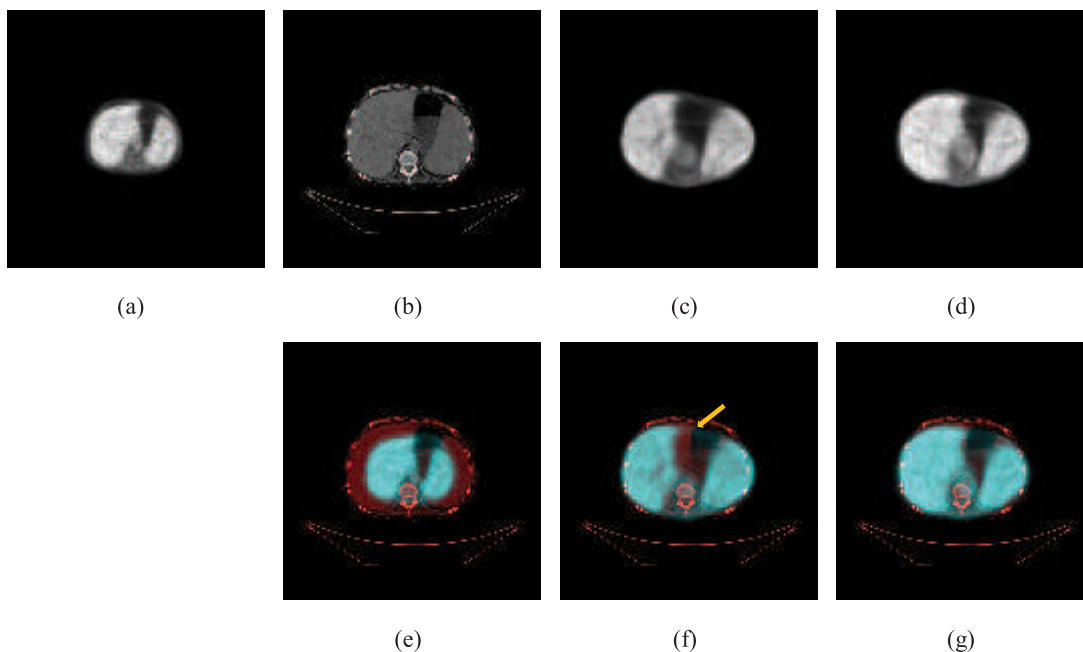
An example of PET/CT registration results with and without distribution similarity (DS) term. (a) The source PET image. (b) The source CT image. (c) The registration result without DS. (d) The registration result with DS. (e) The fusion image of the source PET and CT image. (f) The fusion image of the registered PET and CT image without DS. (g) The fusion image of the registered PET and CT image with DS.
